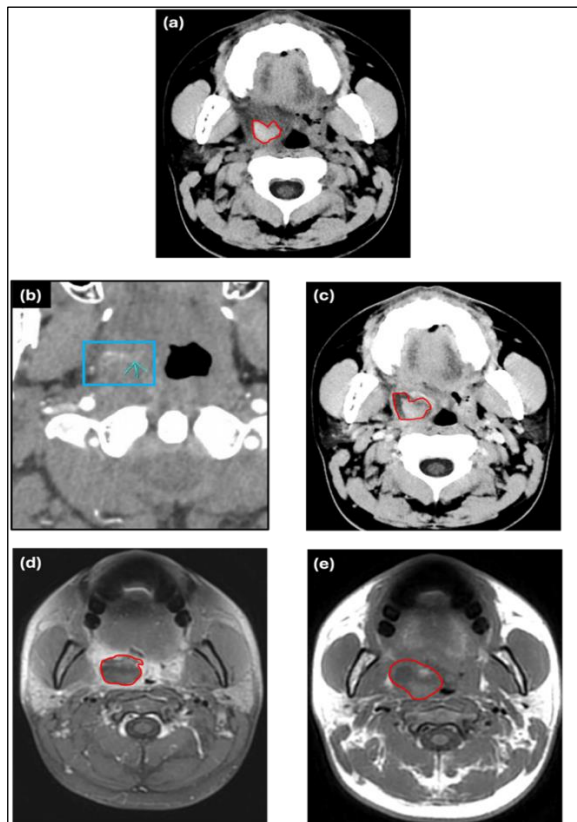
CT imaging of the 26-year-old patient, 5-6 hours post bipolar diathermy of the spontaneous tonsillar hemorrhage. (a) Non-contrast CT shows a well-defined inhomogeneous hyperdense region in the peritonsillar area. (b) CT angiography of the right pharyngeal region, blue rectangle indicating the right tonsillar/peritonsillar space, a 10x25 mm axial spread of contrast from the aberrant artery highlighted with a blue arrow within a blue rectangle, (c) Late post-contrast CT imaging showing the enhancing wall surrounding the lesion (red highlighted area) (d) T1W MRI and (e) contrast-enhanced T1W MRI showing inhomogeneous material in the right tonsil and peritonsillar area (highlighted by the red shape) suggesting hemorrhage and a subacute peritonsillar abscess alongside an erosion of the artery (pseudoaneurysm).
